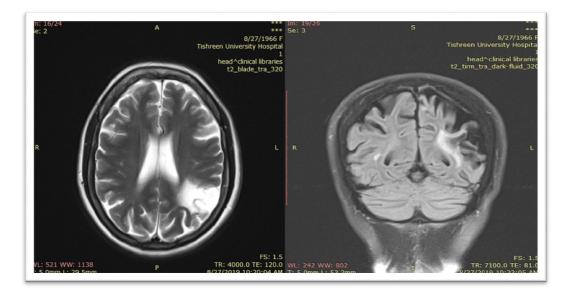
A 53-year-old female was clinically diagnosed with unknown-onset seizure. T2WI in axial plane, FLAIR with coronal oblique plane, and 3D acquisition isotropic IR. Findings are consistent with left gliosis and encephalomalacia
